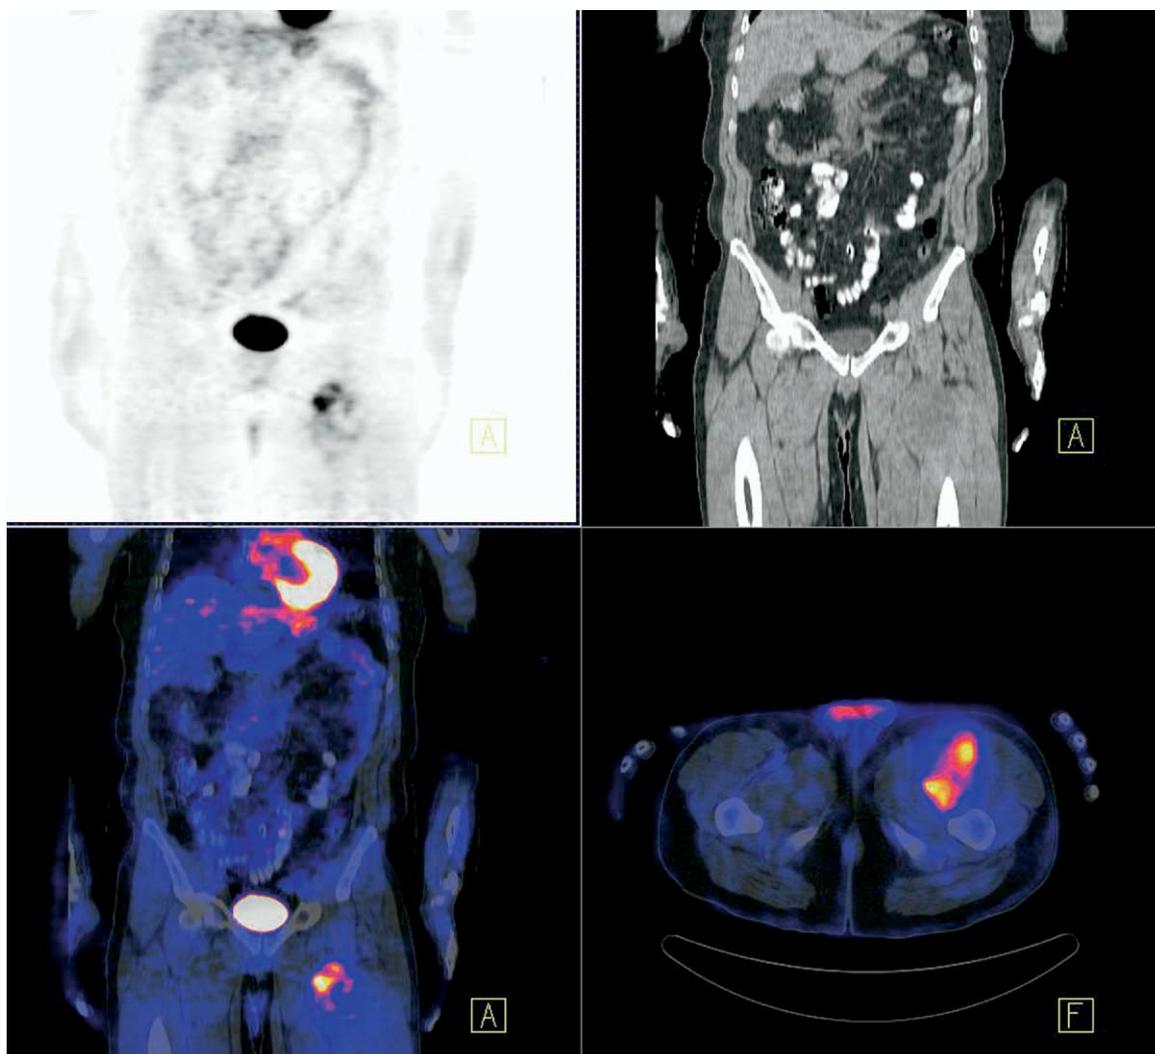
Shown is a 50-year-old male with a left anteromedial thigh liposarcoma. PET-CT shows intense hypermetabolism corresponding to the hypoattenuated tumor mass with a maximum SUV of 6.13. (Color version of figure is available online.)
